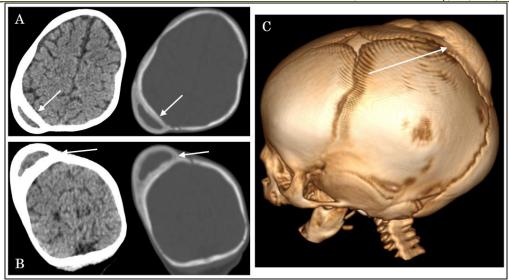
A CT-scan in axial (A) and coronal (B) views with 3D reconstruction (C) a right parietal extra-cranial hypodense collection, unenhanced after contrast administration, and delineated by two osseous layers. The outer layer was in continuity with the calvarium, creating the characteristic "double skull sign"
